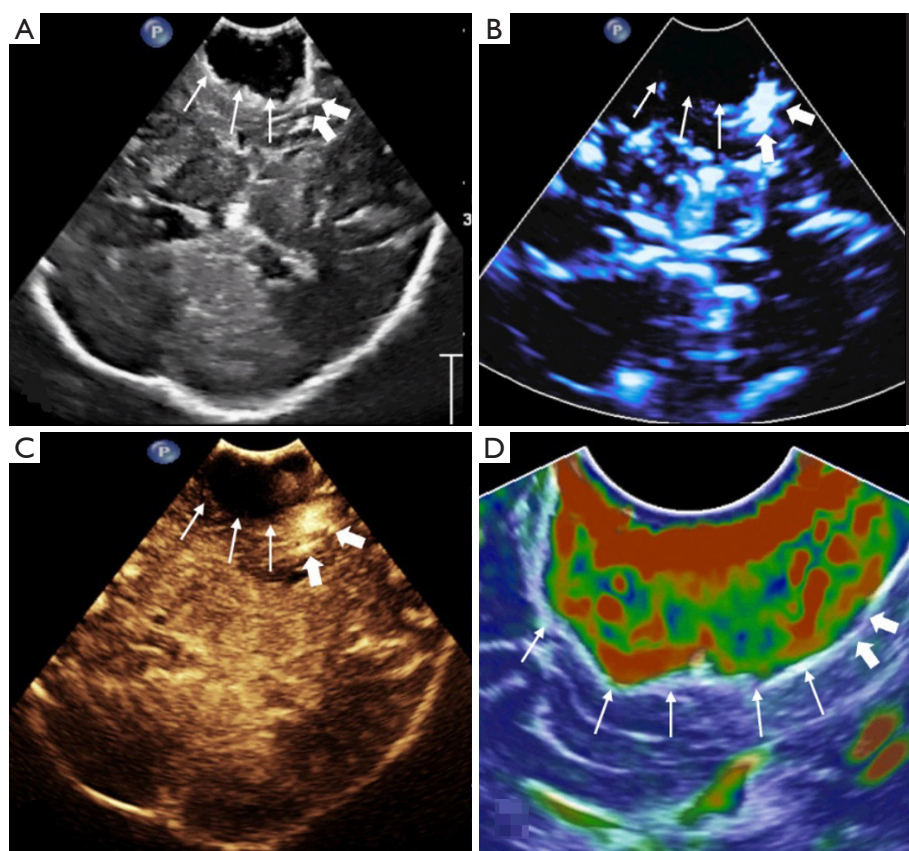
Images of a 68-year-old male with meningioma who had tumor residue after neurosurgery. (A) Unclear tumor residue on the B-mode image; (B) the tumor residue showed rich intralesional vascularization on micro-flow imaging; (C) no tumor residue was shown on the SWE image; (D) the tumor residue showed high enhancement on the CEUS image. Thick arrows indicate the tumor residue; thin arrows indicate the surgical cavity. CEUS, contrast-enhanced ultrasound; SWE, shear wave elastography.
